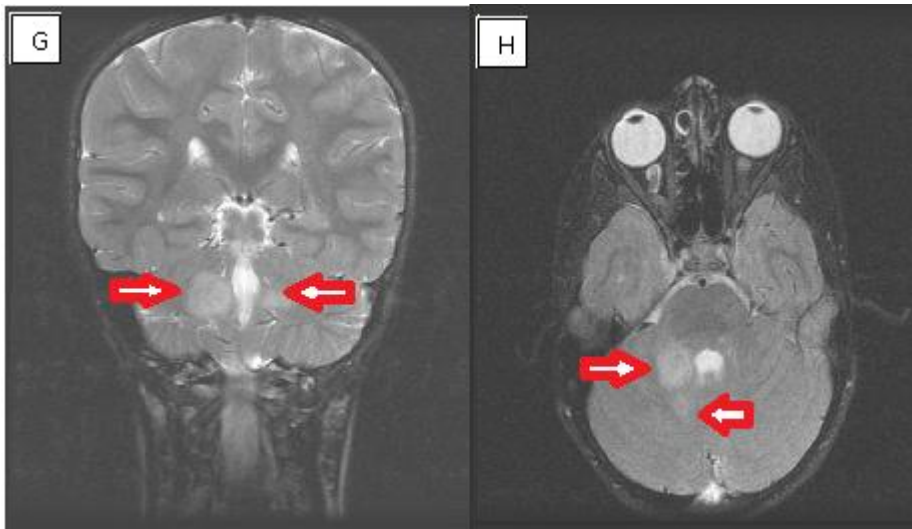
MRI scan (coronal view; G) showing a spongiform gliose in the cerebellum, high brainstem, and (axial view; H) hypothalamus (NF1 Individual Code 004).
